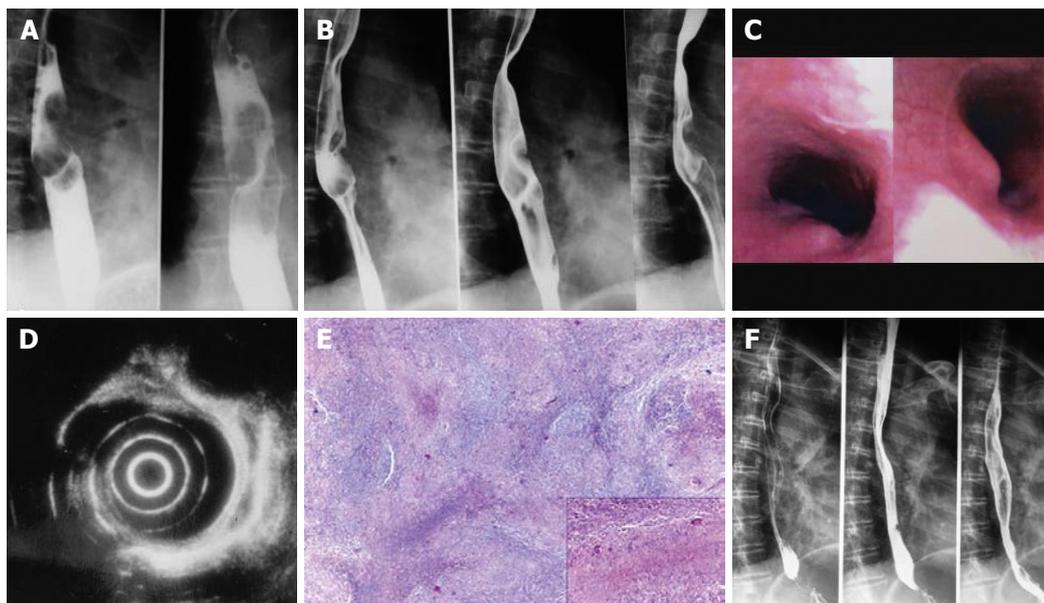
A barium swallow esophagogram disclosing a four-centimeter protruding smooth lesion with apparent integrity of mucosa on the mid-esophagus (A, B), esophagoscopy showing a two-centimeter deformity of the esophageal wall covered by normal mucosa and with firm consistency, twenty-two centimeters from dental arch (C), endoscopic ultrasonography revealing a two-centimeter well defined solid tumor in the fourth layer (D), lymph node parenchyma extensively occupied by necrotizing epithelioid granulomas (HE, $\times 40$) and typical tuberculous granuloma with central caseous necrosis and multinucleated cells of Langhans type (HE, $\times 200$) (E), and a two-month follow-up after surgery revealing no filling defect at the same level (F).
